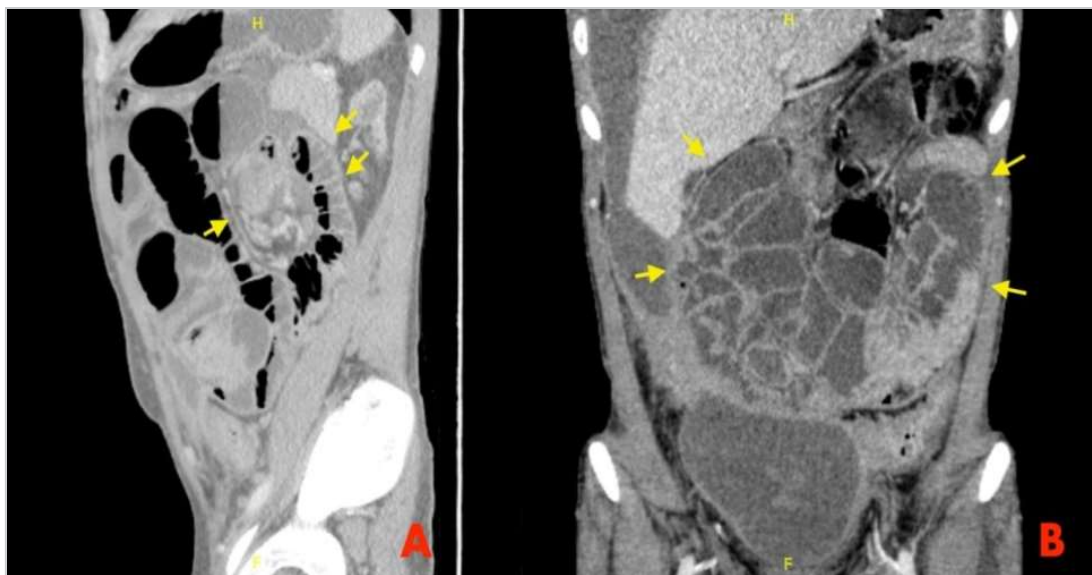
A: Axial CT with no contrast reveals air fluid levels consistent with blockage and dilated bowel loops (arrows). B: Coronal CT scan with no contrast with any contrast reveals an abdomen filled with fluid that is encircled by an enhanced, thickened peritoneum
